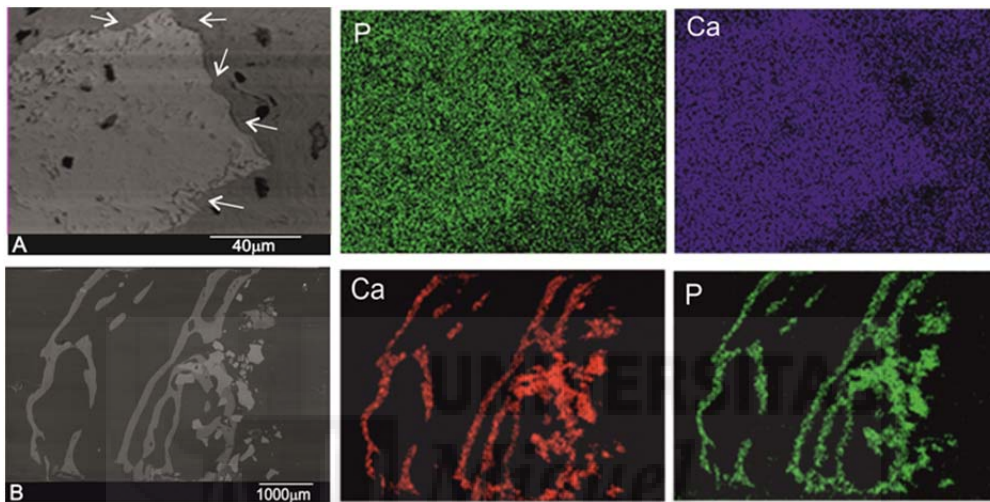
SEM image of polished cross-section of a biopsy. A- BBM. B- PBM xenograft material after 6 month implantation and elemental X-ray maps of Calcium and Phosphorous. [Arrows refers to irregular boundary with partial degraded implant]
